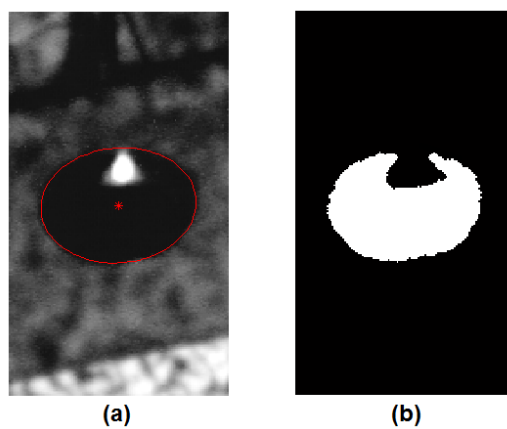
ROI of the optical system's photo including the elliptic feature used for the tracking of CBCT panel motion (Panel a). The red star represents the centre of the ellipse fitted to the vertices of the convex hull extracted from the thresholded feature of interest (Panel b).
